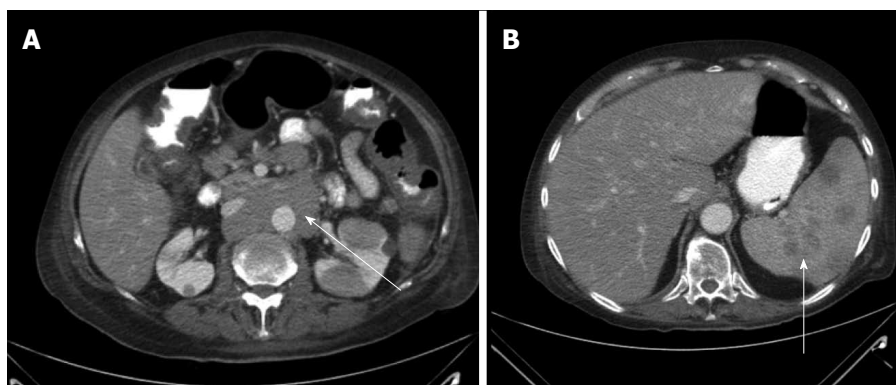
Abdominal computed tomography scan. A: Showing the confluent non-compressing circumaortic mass (arrow); B: Showing multiple hypodense splenic lesions (arrow).
